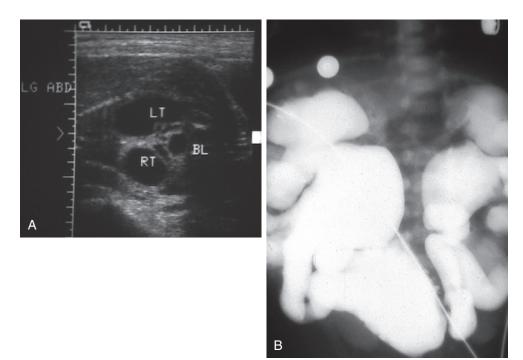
Fetal hydronephrosis. A, Fetal ultrasonography performed to assess gestational age reveals bilateral fetal hydronephrosis and a distended bladder. B, Voiding cystourethrogram reveals posterior urethral valves and severe bilateral vesicoureteric reflux. BL, bladder; LT, left kidney; RT, right kidney.
